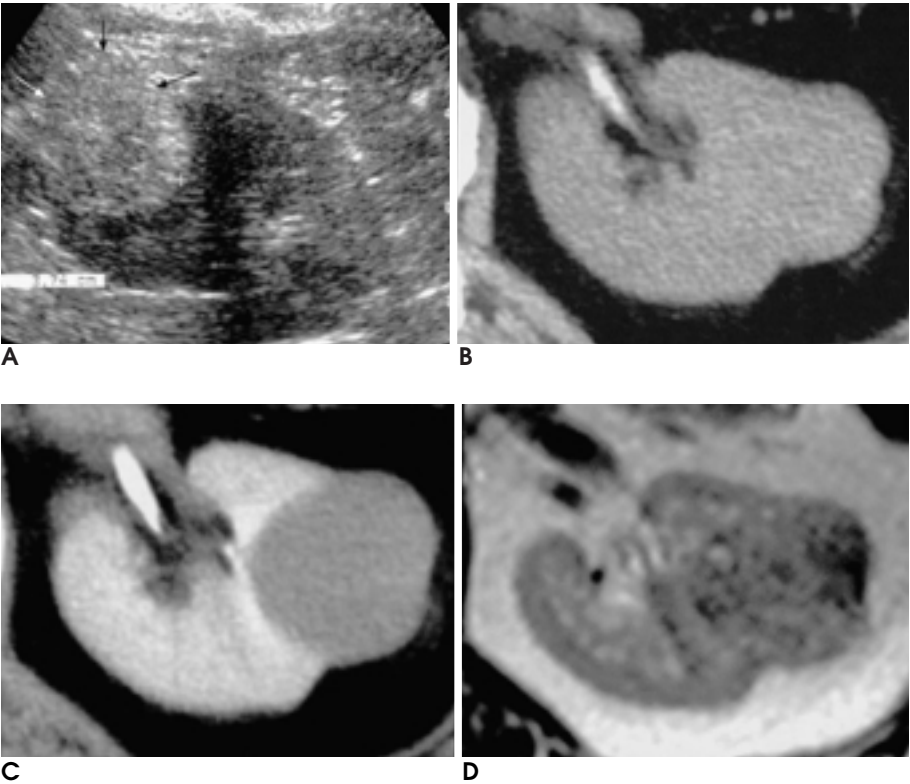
A 56-year-old-woman with renal cell carcinoma. Renal ultrasonogram (A) shows a round hyperechoic mass lesion (arrows). An isodense mass lesion with contour bulging on non-enhanced CT scan (B) was minimally enhanced on enhanced scan (C). On T2-weighted MR image (D), the mass lesion is isointense to the renal cortex.
